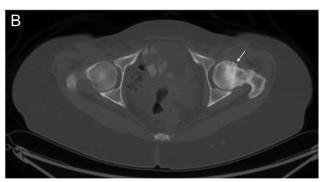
Surveillance PET-CT scan obtained a year after the presentation to the oncology orthopedic service (2020), coronal (A) and axial view (B) depicting the left femoral neck healed fracture (arrow) that remained in a stable position.
